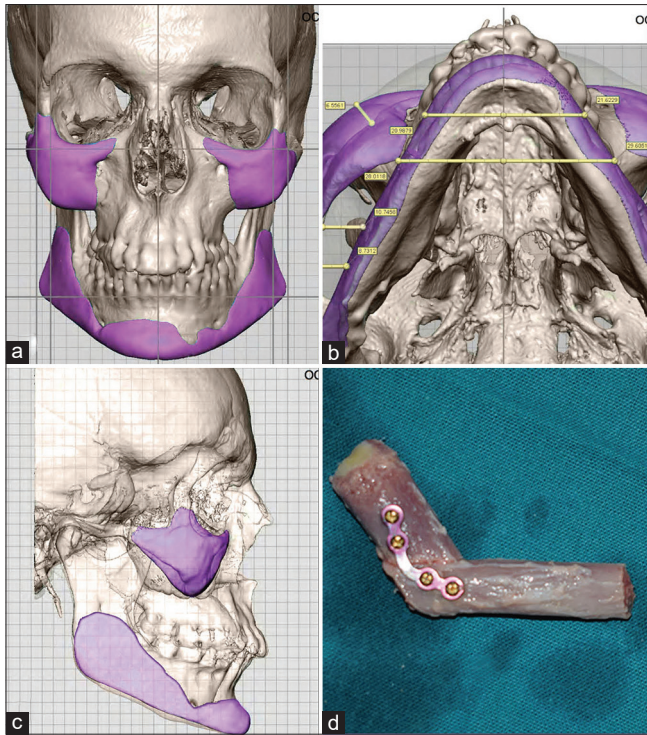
(a-c) Three-dimensional computed tomography skull views showing the treatment plan for zygoma and mandible augmentation using bone graft. (d) Rib graft crafted in “L” shape for mandibular body, ramus augmentation, and angle creation
